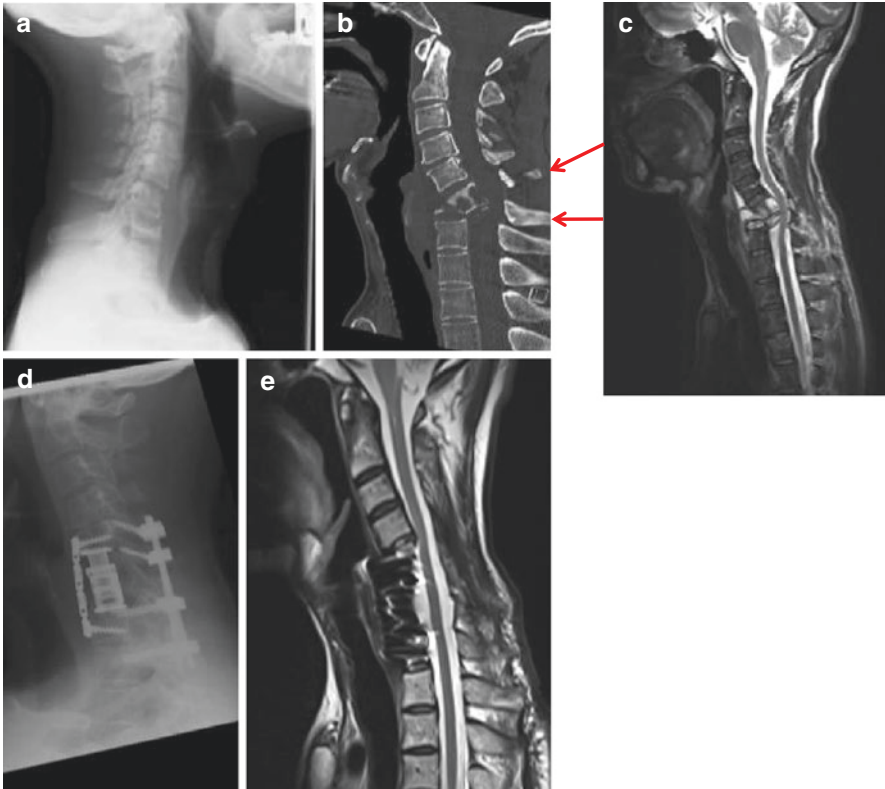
48 year-old man with 9 months of neck pain who had initially presented to his emergency department 4 months previously with the same neck pain (a) he was discharged with a diagnosis of degenerate spondylosis. Represented with worsened neck pain CT (b) and MRI (c) show complete destruction of C7 vertebral body and partial destruction of C6 (note the two red arrows pointing to the spinous processes of C6 and C7) with retrolisthesis and canal compromise without neurological deficit. He was initially fitted with a HALO brace and started on TB Chemotherapy. After 2 weeks of treatment when it was felt that the disease burden had been reduced he underwent an anterior and posterior fixation where the deformity was corrected. [Post OP x ray (d) and MRI (e)]
